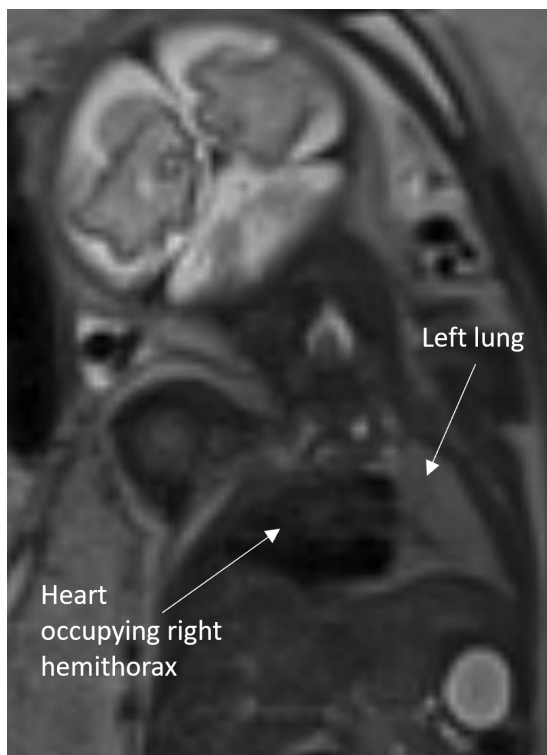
T2 HASTE Coronal MRI image of right lung agenesis in 32 week fetus
